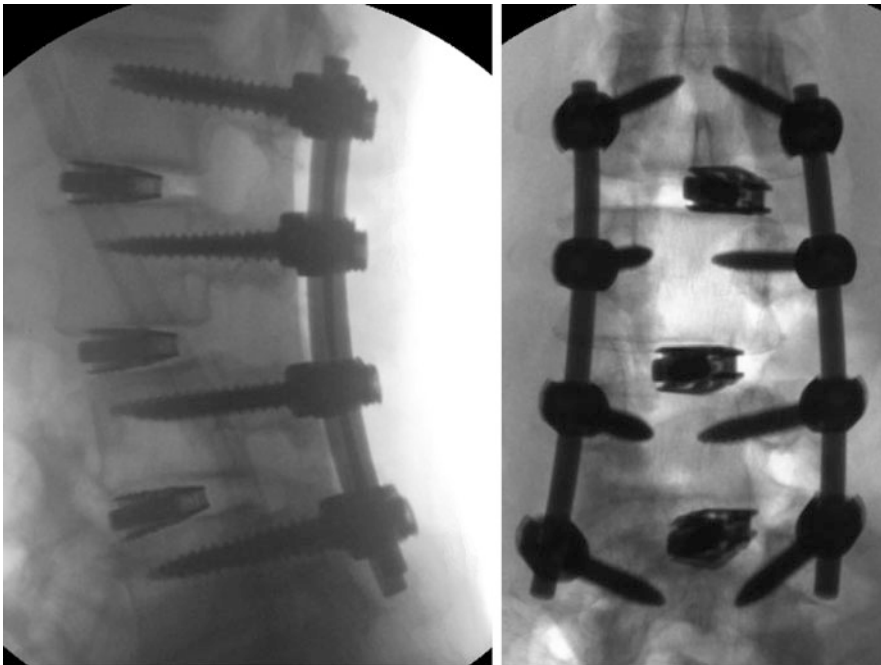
Intraoperative lateral and AP x-rays demonstrating open L2–5 pedicle screw fixation and interbody fusion with expandable cages to restore foraminal height as well as segmental lordosis
